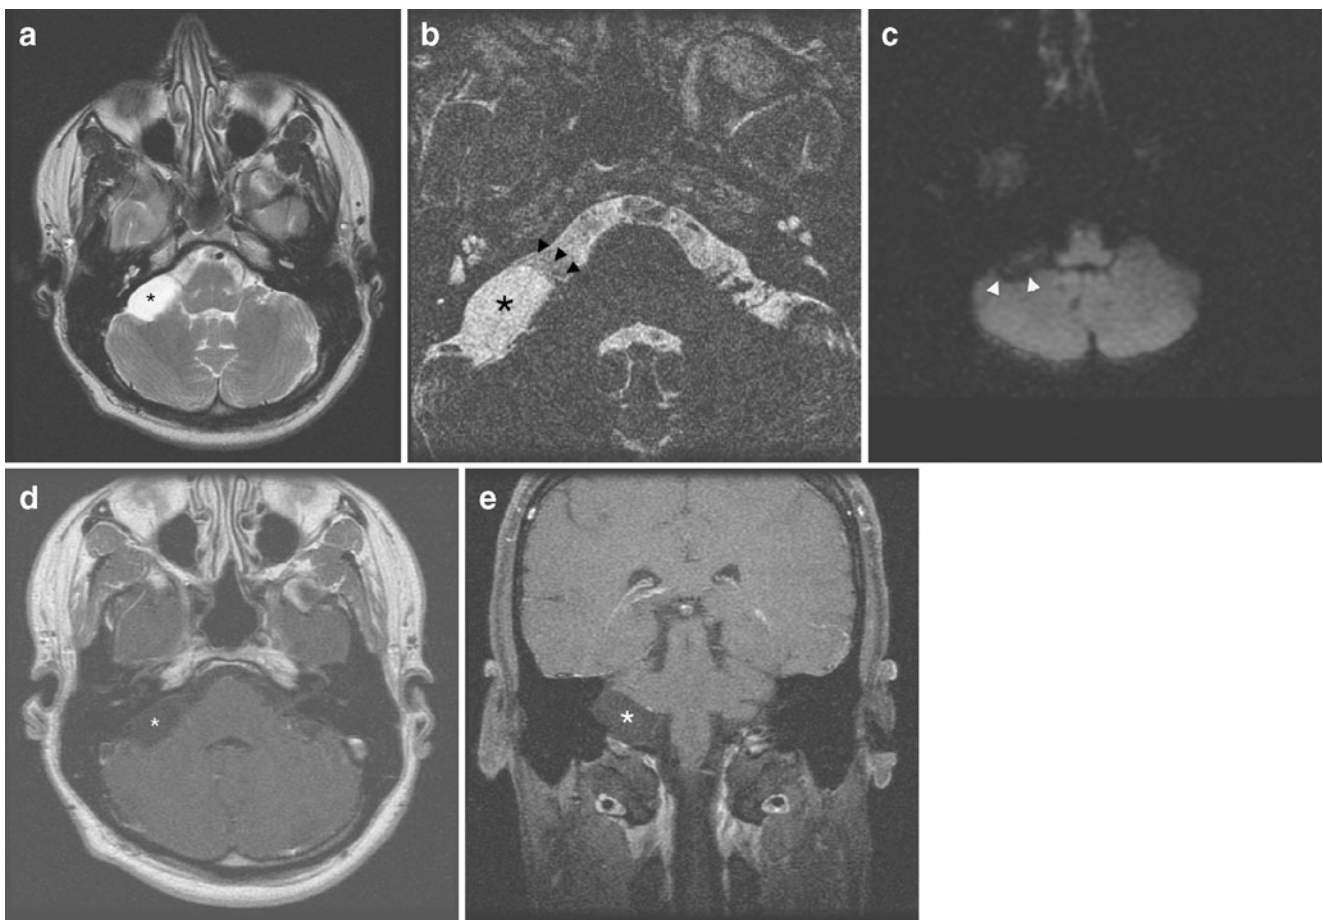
A 55-year-old male investigated for sensorineural hearing loss on the left side. a Axial 4-mm-thick TSE T2-weighted MR image through the posterior fossa. In the posterior part of the right CPA, a nodular homogeneous hyperintense lesion is found (*asterisk*). The intensity is homogeneous and the lesion is sharply delineated. b Axial 1-mm-thick 3D TSE T2-weighted MR image through the posterior fossa. The lesion is situated in the posterior and lateral aspect of the right CPA, showing a homogeneous hyperintensity (*asterisk*). There is anterior displacement of the right vestibulo-cochlear and facial nerve (*arrowheads*). c Axial 4-mm-thick EP DW b1000 image. The lesion
